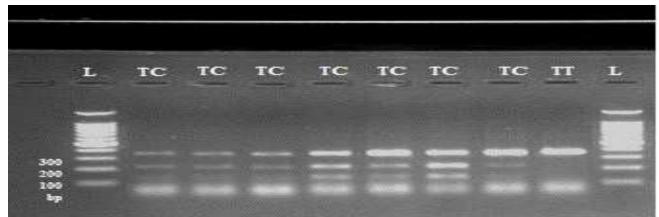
E-Selectin rs5368 (C468T) PCR Product after Treatment with CviAII Restriction Enzyme (One band: 353bp =TT; Two bands: 219 + 134bp = CC; Three bands: 353 + 219 + 134bp = CT), 2 % agarose gel electrophoresis for 3hrs, 300 volts
